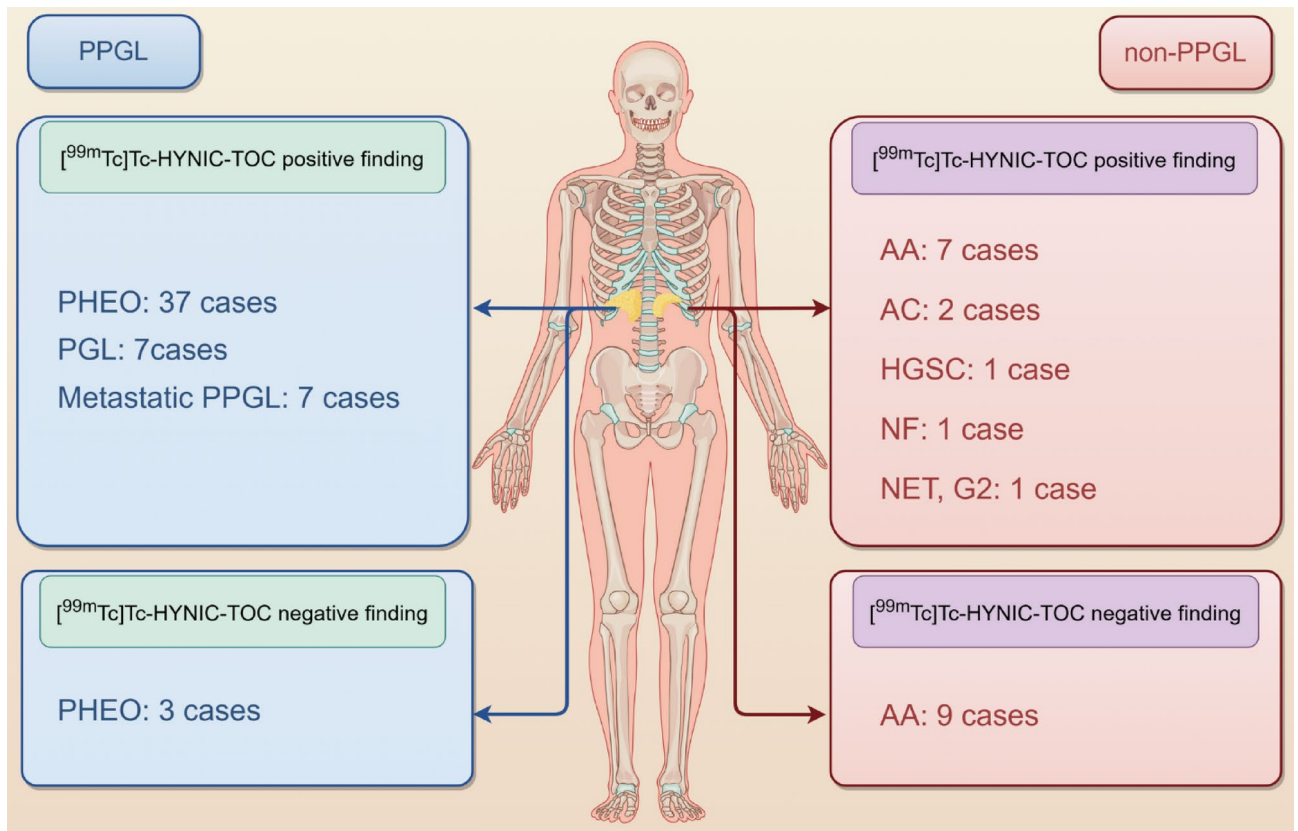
Summary of [^{99m}Tc]Tc-HYNIC-TOC SPECT/CT finding in PPGL and non-PPGL.
